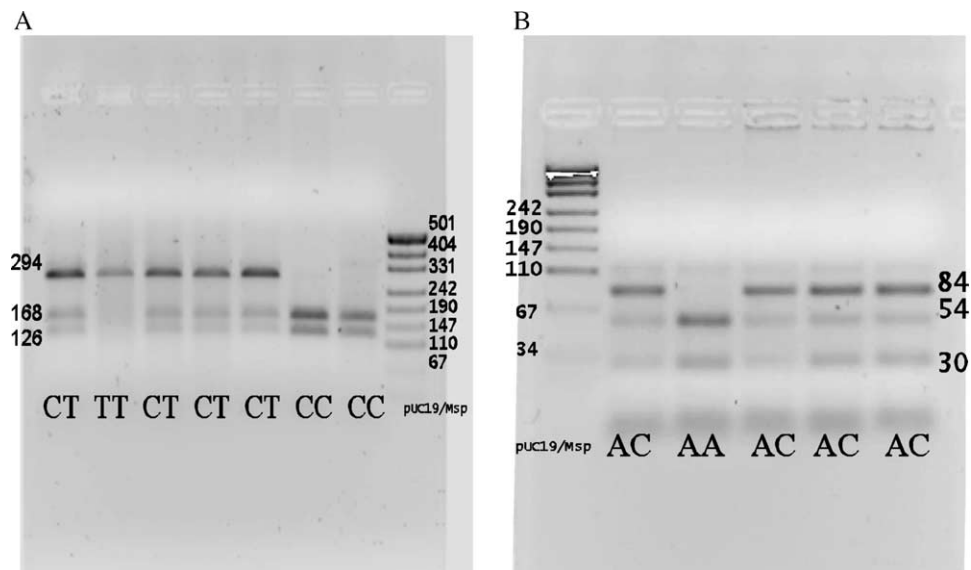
(A) PCR-based RFLP analysis of the MTHFR (codon 222) polymorphism. The CC lines represent a homozygote sample (MTHFR 677 CC, wild-type) where both alleles contain a C at position 677; whereas the CT lines represent a heterozygote where one allele contains a C and the second allele contains a T at position 677; the TT line represents a homozygote where both alleles contain a T at position 677. (B) PCR-based RFLP analysis of the MTHFR (codon 429) polymorphism. The AA line represents a homozygote sample (MTHFR 1298 AA) where both alleles contain an A at position 1298, whereas the AC lines represent a heterozygote where one allele contains an A and the second allele contains a C at position 1298.
